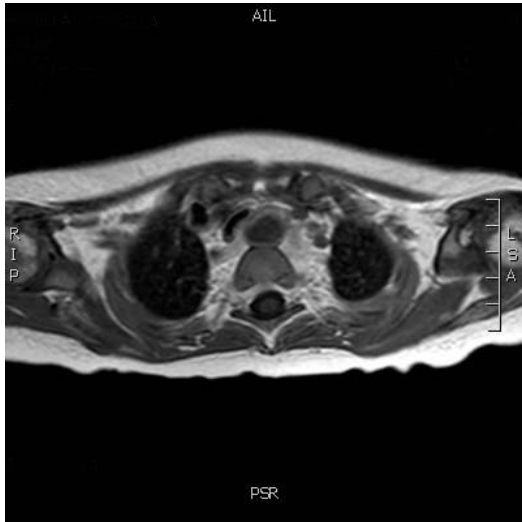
Cervical MRI, axial image that shows tracheal compression and stenosis.
